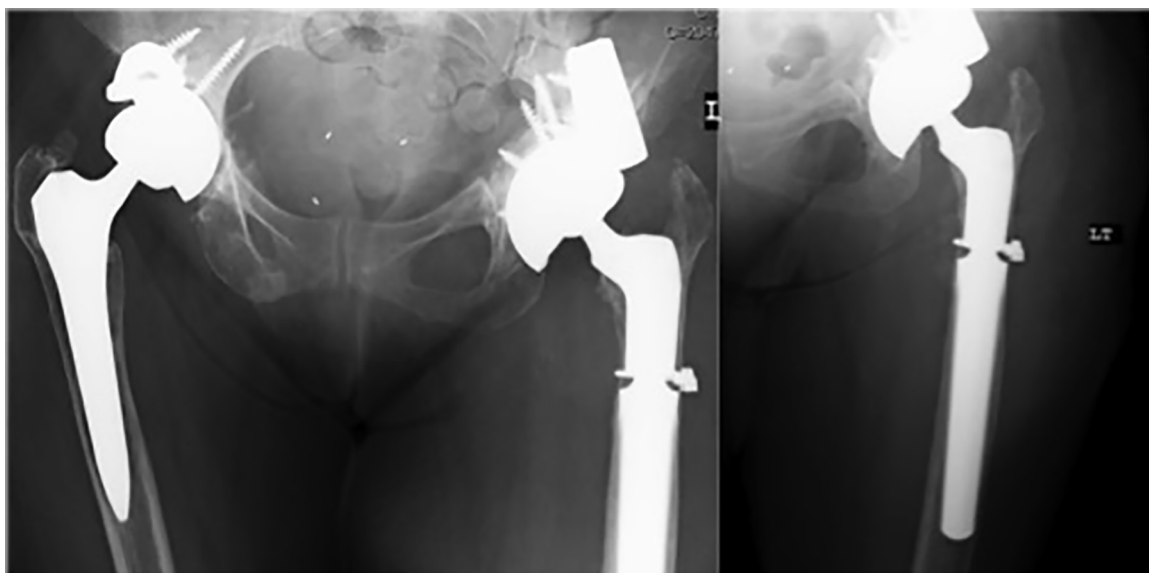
Pelvic AP radiograph and AP of the left hip status post left sided THA replant with a “Cup-in-Cup” construct, Trabecular metal augment, dual-mobility head, and a distal fixation modular cementless femoral revision stem.
